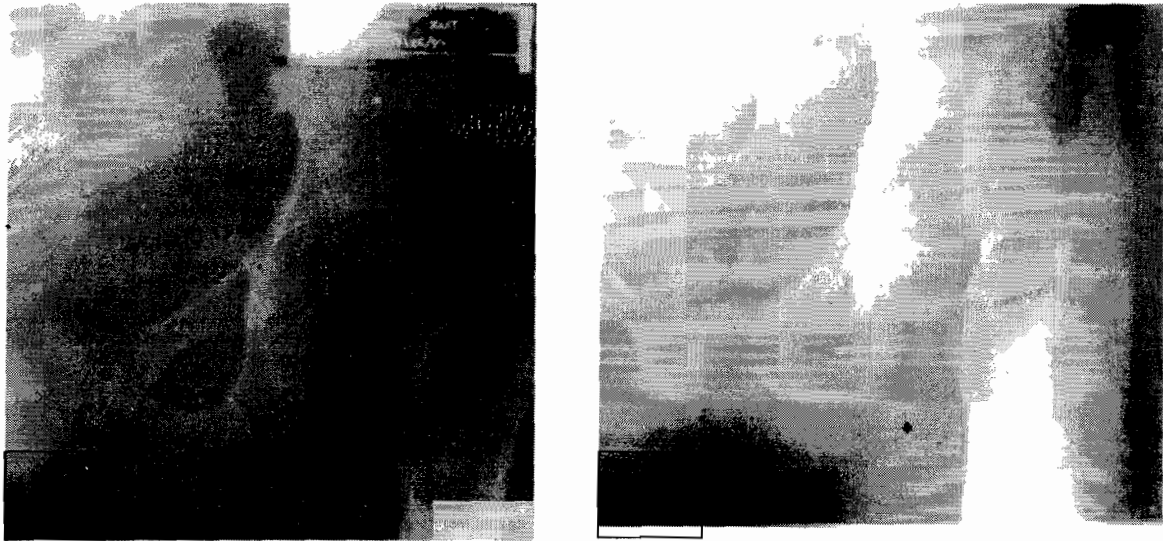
Plain X-ray of Mrs I.M. 4 weeks after delivery showing posterior dislocation of the left femur and symphyseal diastasis
